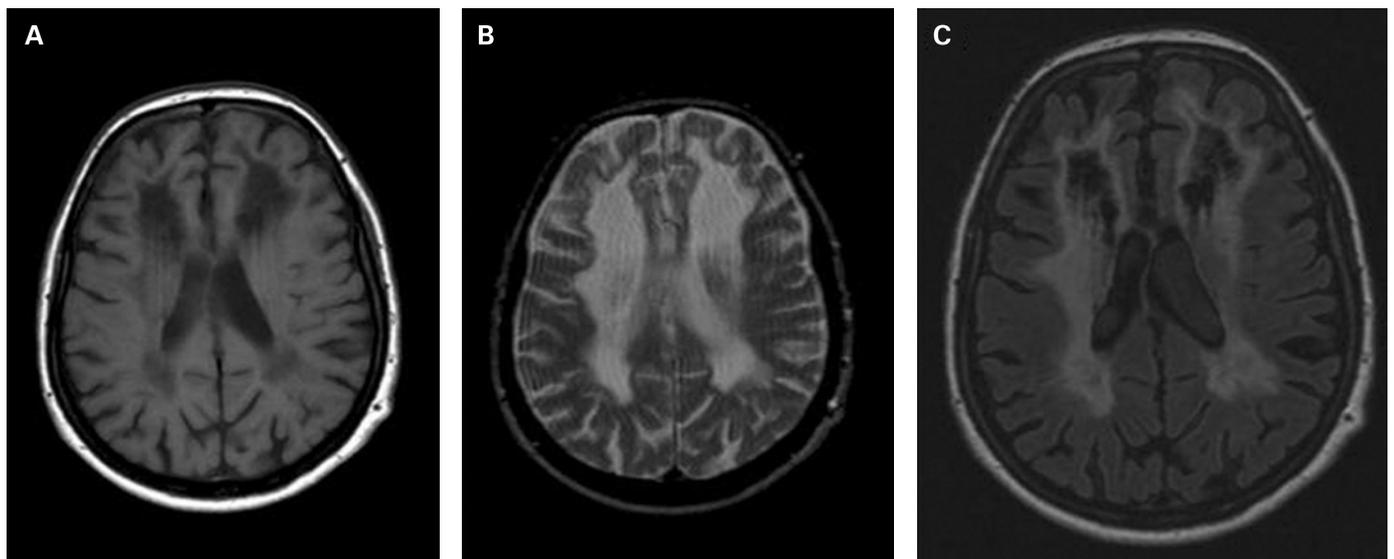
MRI showing severe diffuse leukoencephalopathy with cystic degeneration and a signal similar to cerebrospinal fluid. (A) T1, (B) T2 and (C) fluid attenuated inversion recovery sequences.
